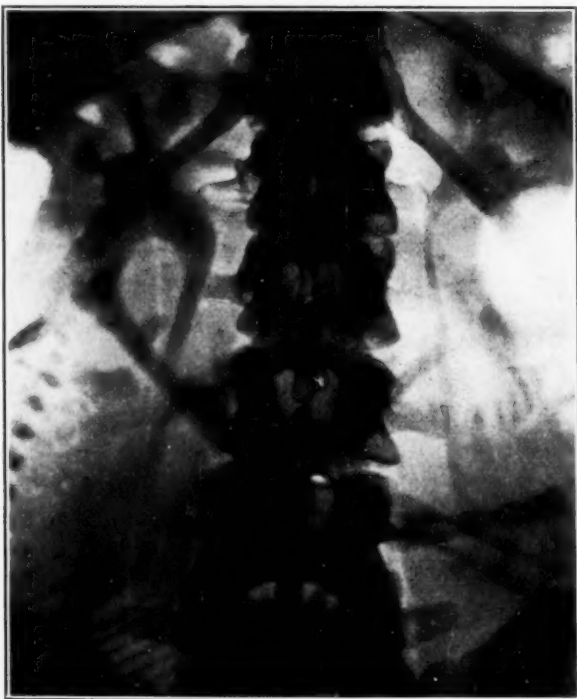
Case 14310. Patient aged thirty, para I, grav. II, had a normal pregnancy of seven months' duration. She had no kidney complaints. The roentgenogram was taken three hours after the injection. Note the retention of the dye after this long period.
